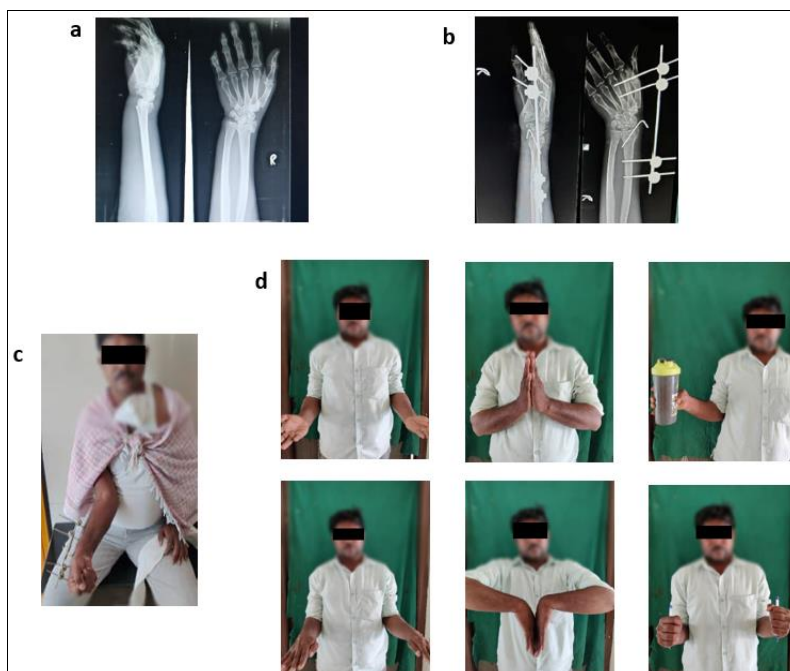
Case 2: a. Pre-operative X-Rays. b. Post-operative X-Rays. c. Post-operative clinical photo. d. Supination, Dorsi Flexion and Grip Strength (Up, left to right), Pronation, Palmer Flexion and Grip Strength (Down, left to right)
